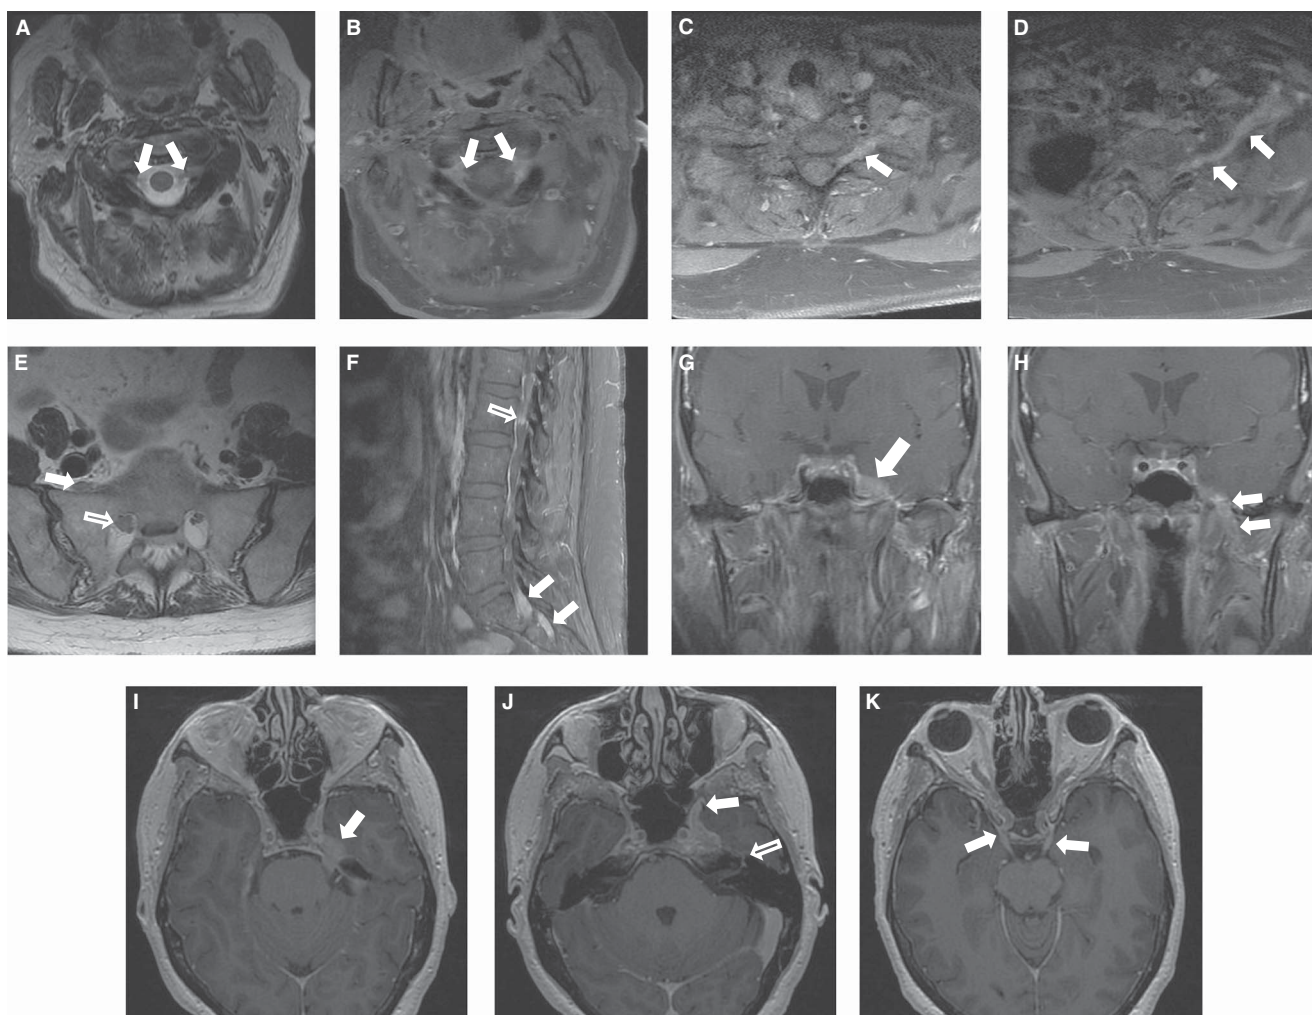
Axial T2-weighted magnetic resonance (MR) (A) and postgadolinium T1 fat-saturated (fatsat) images (B) show abnormal thickening and enhancement of the C2 nerve roots bilaterally (arrows). Axial postgadolinium T1 fatsat shows abnormal thickening and enhancement of the left C8 (arrow in C) and left T1 nerve root and proximal lower trunk of the brachial plexus (arrows in D). Axial T2-weighted MR image of the sacrum (E) demonstrates abnormal enlargement of the extraforaminal right L5 nerve root (arrow) and the S1 nerve root (open arrow). Sagittal T1 postgadolinium fatsat MR image (F) shows abnormal thickening and enhancement of these nerve roots (arrows). Abnormal enhancement of the right L2 nerve root is also evident (open arrow). Coronal postcontrast T1-weighted MR images demonstrate enhancing tumor distending the left Meckel cave (arrow in G), whereas there is only subtle enhancing tumor in the right side. More anteriorly, marked enhancement and thickening is noted of the left mandibular division of the trigeminal nerve as it descends through foramen ovale (arrows in H). (I) Axial postcontrast T1-weighted MR image demonstrates thick abnormal enhancement of the left cisternal segment of the trigeminal nerve extending to Meckel cave. (J) Axial postcontrast T1 more inferiorly shows tumor extending along foramen rotundum bilaterally although thicker on the left (arrow). There is also more subtle tumor spread along the greater superficial petrosal nerve to the left geniculate ganglion (open arrow). (K) Axial postcontrast T1-weighted MR image demonstrates symmetric abnormal enlargement and enhancement of the cisternal segments of the oculomotor nerves (arrows).
